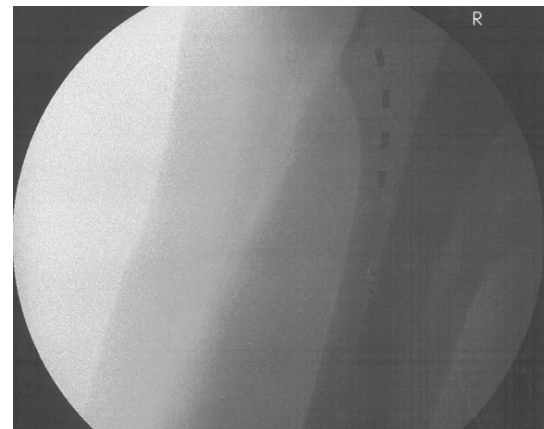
X-ray of device placement.
